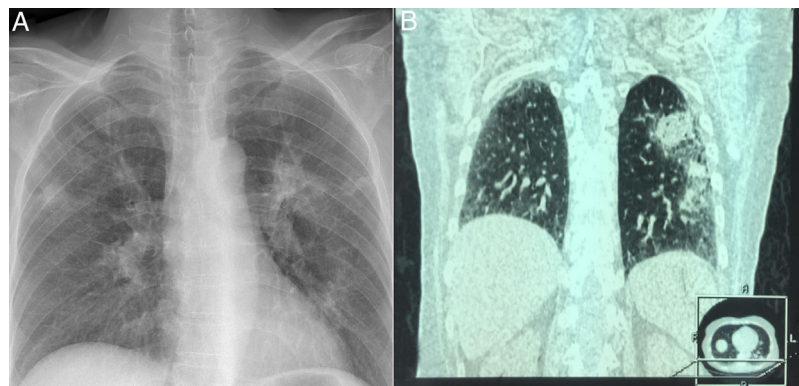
Chest X ray showing abscessus pneumonia (A); HRCT demonstrated extensive pulmonary abscessus over both the lungs (B).
